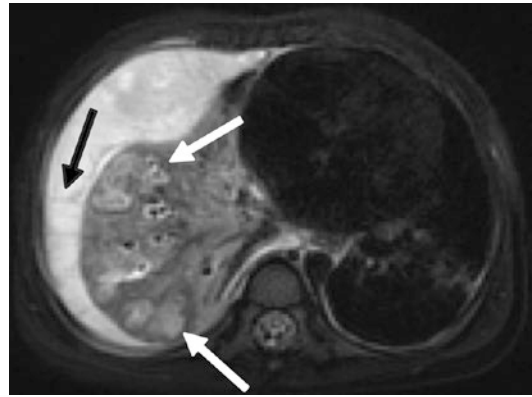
A 3-year-old child with complicated pneumonia. T2-weighted MRI sequence clearly delineates intrapulmonary abscesses as focal areas of increased intensity with a hypointense rim in the right lower lobe (*white arrows*) and a large septated pleural effusion consistent with empyema (*black arrow*)
